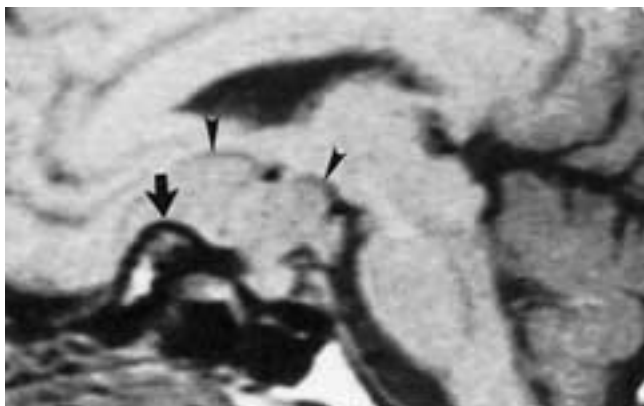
Suprasellar planum sphenoidal meningioma. Sagittal T1-weighted image shows a slightly hypointense suprasellar mass (*arrowheads*). Hyperostosis of the planum is present (*arrow*).
